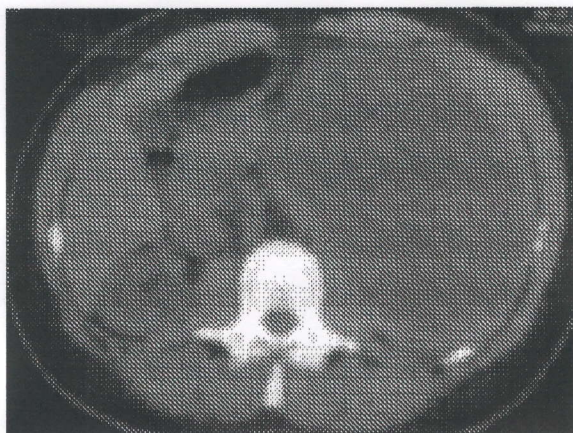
Computed tomography scan of the abdomen showing a large splenic cyst that displaced intraperitoneal and retroperitoneal anatomical structures from left to right (transverse section).
